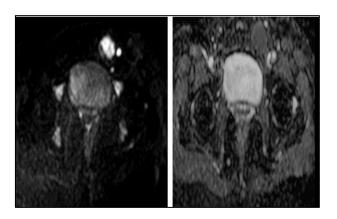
The mass lesion was showing diffusion restriction on DWI/ADC images.
